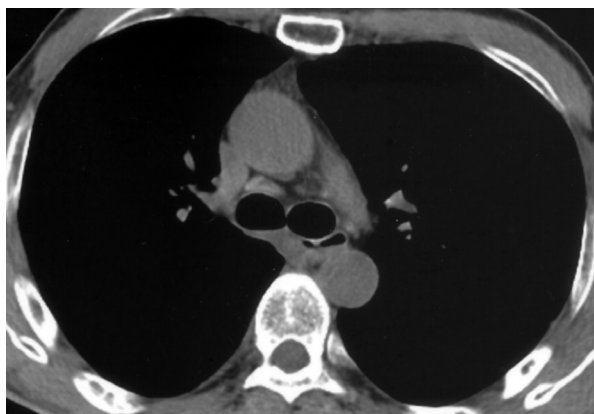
Chest CT without contrast enhancement in a mediastinal window view shows a stationary mediastinal lymph node, compared with the pre-treatment chest CT.
